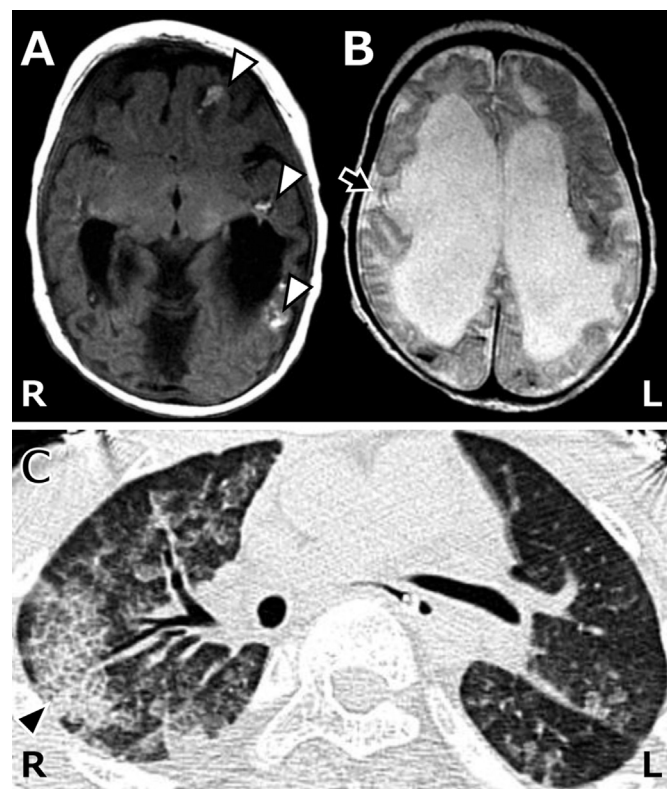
The clinical images of the patient. Brain MRI at 1 month of age showed multiple hemorrhage (white arrowheads) and open-lip schizencephaly (black arrow). A) T1-weighted imaging; B) A T2-weighted imaging. C) Alveolar hemorrhage at 9 years of age. A chest CT scan showed ipsilateral ground-glass opacity and interlobular septal thickening (black arrowhead). R: right, L: left.
